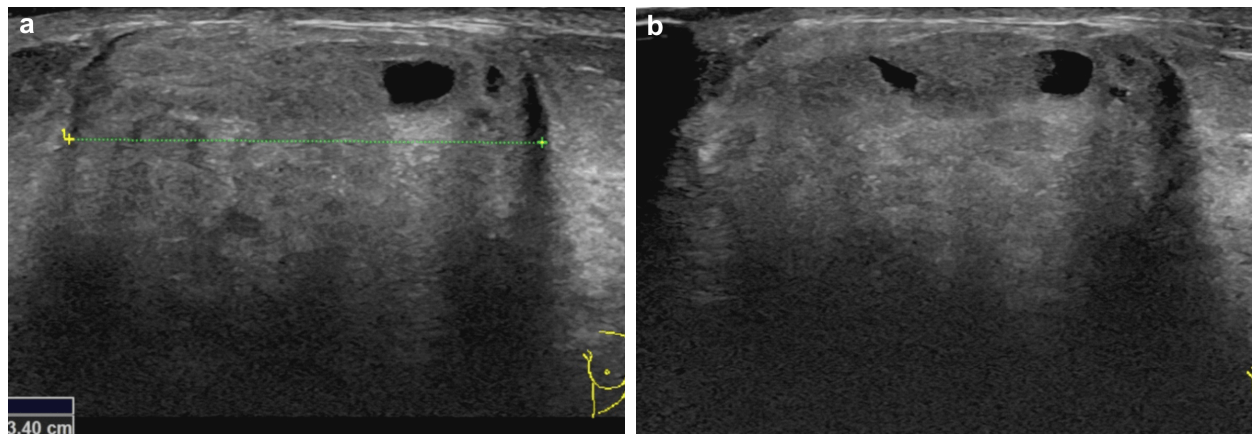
(a and b) Ultrasound examination of the left breast showing a large, well-defined, isoechoic mass, heterogeneous, with eccentric cystic spaces (BI-RADS 4a). BI-RADS: Breast imaging-reporting and data system.
